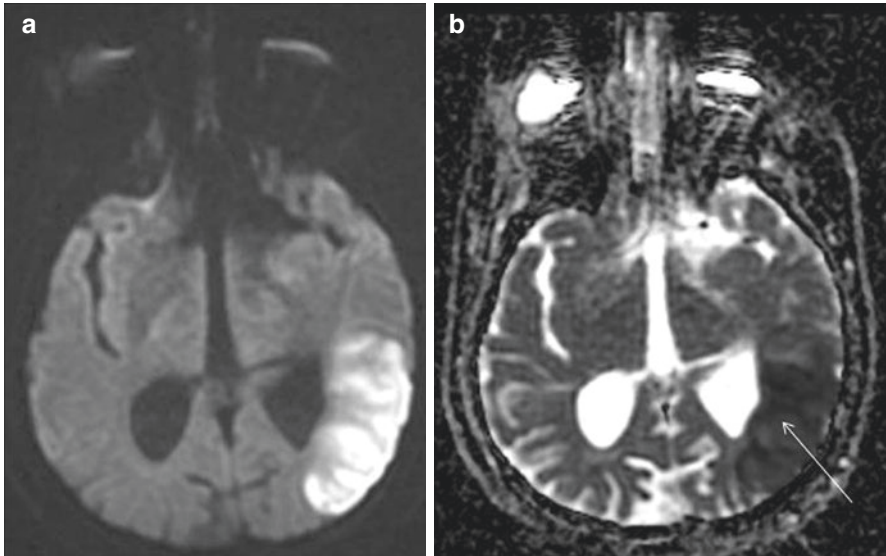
An acute occipital-temporal infarction as captured by (a) diffusion-weighted imaging (DWI) and (b) the apparent diffusion coefficient (ADC) map
